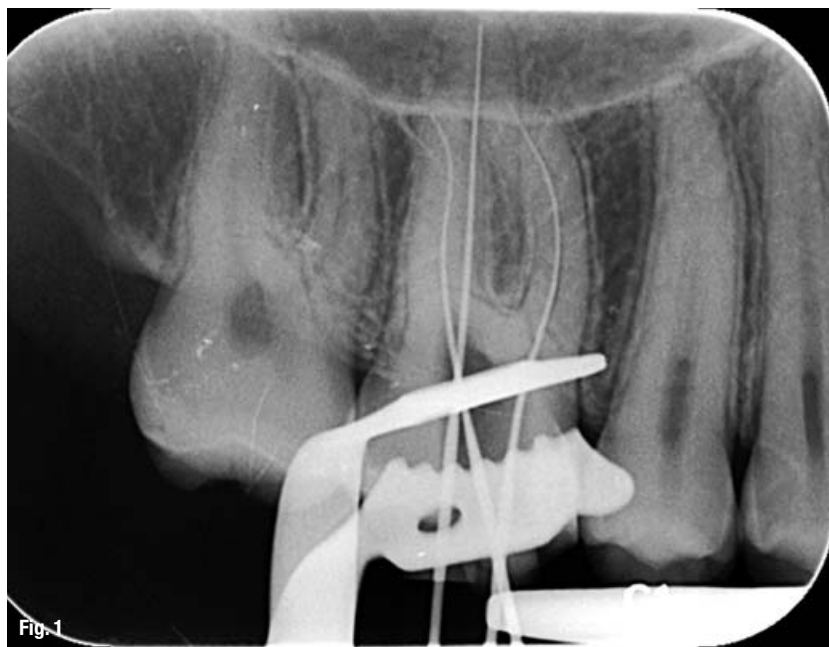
Maxillary molar with files in each root to lengths determined by Root ZX (J. Morita); note the curvatures in the MB and DB canals, as well as the lengths in the palatal and DB canals that are short of the radiographic root apices but at the termini of those canals.
